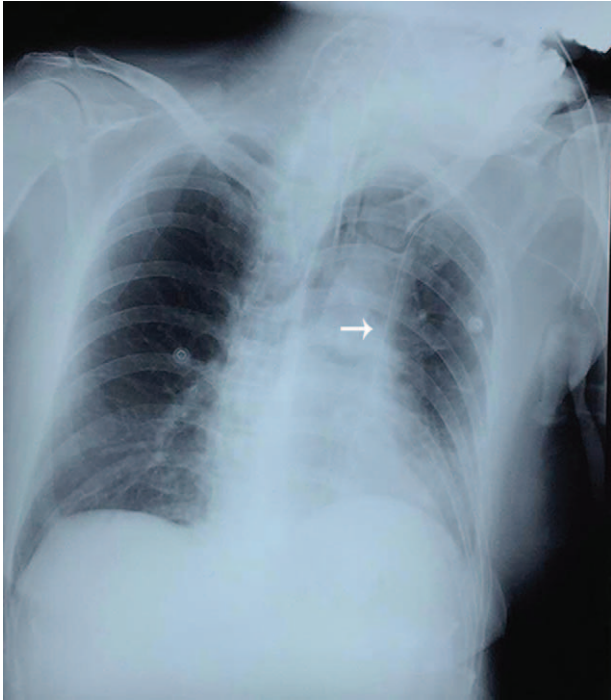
Chest radiograph demonstrating peripherally inserted central venous catheter located in persistent left superior vena cava (white arrow).
